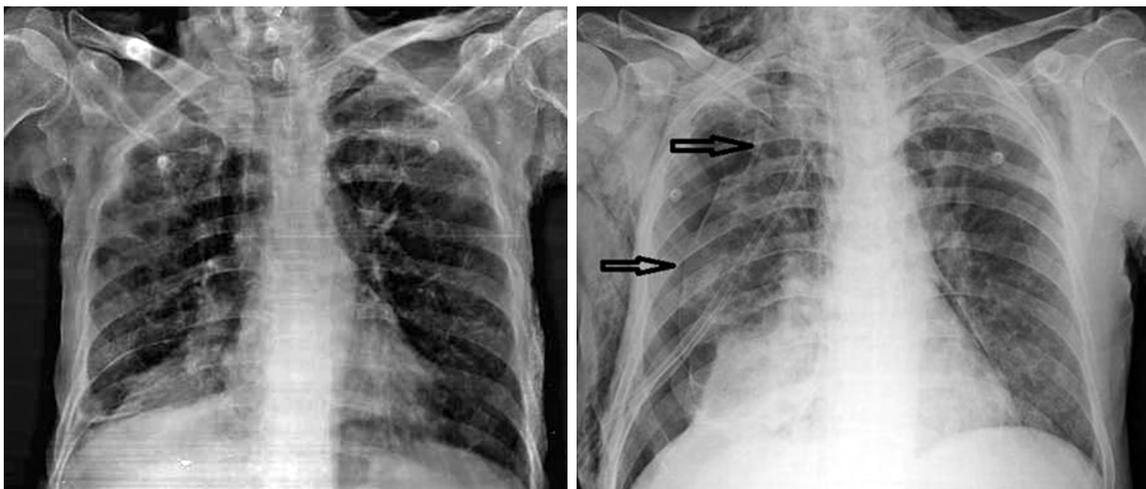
Chest X-ray images showing autologous blood patch technique in patients with a non-expandable lung and persistent air leak and achieving successful results.
